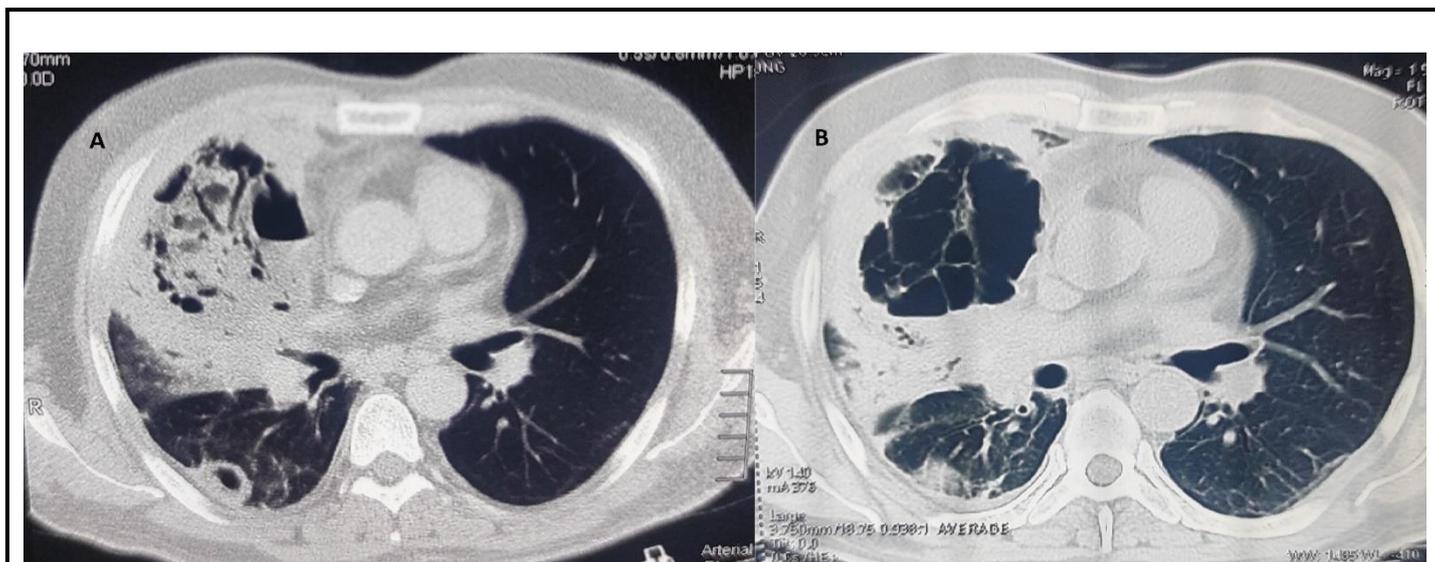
Axial chest CT scan shows (A) dense consolidation with cavity forming lesion involving the right upper lobe. (B) Repeat chest CT on day 12 showed increased chest cavity size and well-defined cavity developed as compared to previous chest CT.
